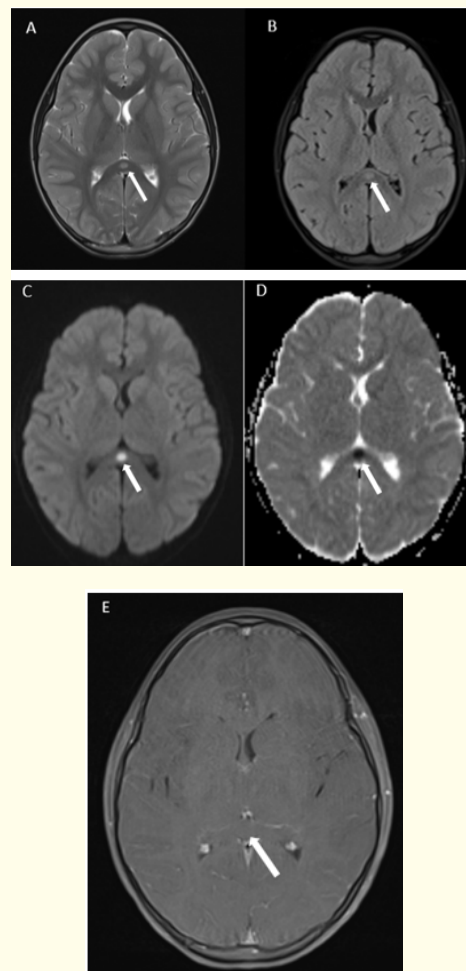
1E: Axial brain MRI showing a well-defined, rounded cytotoxic lesion of the splenium of the corpus callosum, appearing hyperintense on T2-weighted (1A) and T2 FLAIR (1B) sequences, with diffusion restriction on DWI (1C) and corresponding low signal on the ADC map (1D). No enhancement is observed after contrast administration on post-contrast T1-weighted imaging (1E) (white arrows).
